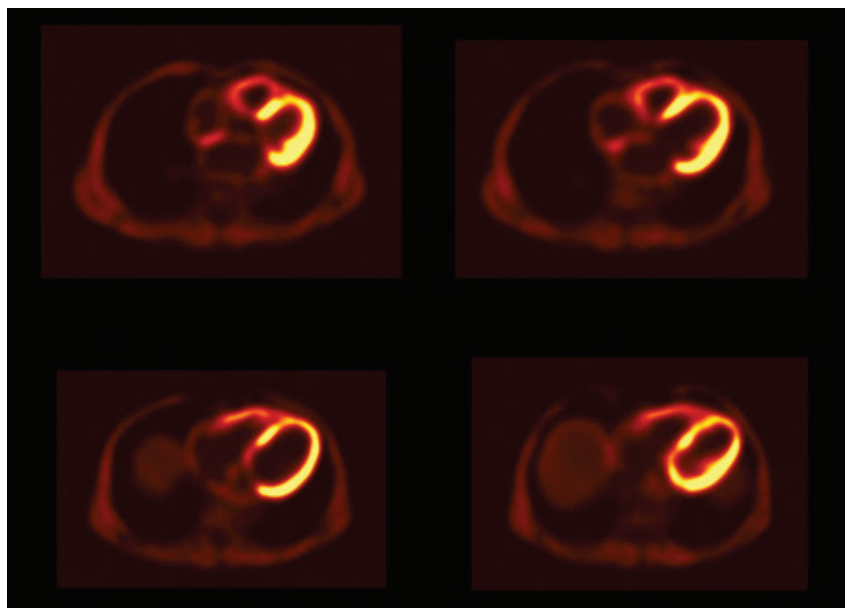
Summed- $^{18}\text{F}$ -FDG-PET-axial images show slightly lower, but preserved  $^{18}\text{F}$  FDG uptake in the septum and anterior wall.
